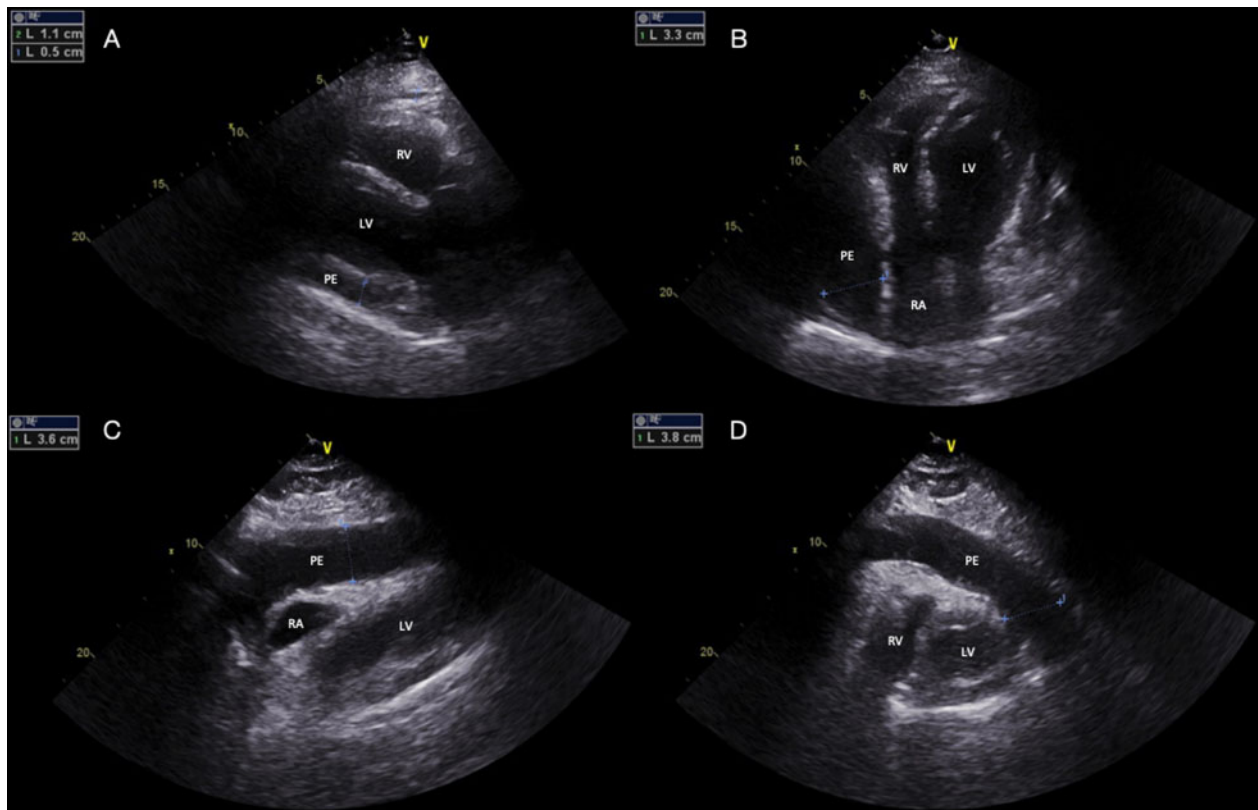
Transthoracic echocardiogram demonstrating the large pericardial effusion dimensions. (A) Parasternal long-axis with 11 mm posterior to the left ventricle. (B) Apical four-chamber with 33 mm anterior to right atrium. (C) Subcostal window with 36 mm anterior to right ventricle. (D) 38 mm apically in subcostal SAX.
